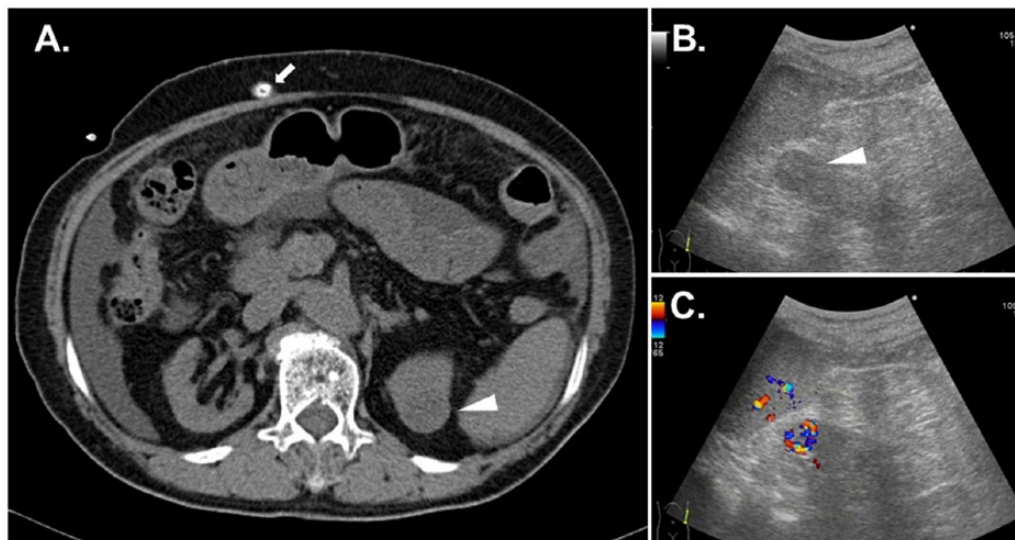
Findings of the imaging studies. A select axial image of a noncontrast abdominal computed tomographic scan (A) shows a solid mass with hypodense appearance deforming the contour in the upper pole of the left kidney (arrowhead). Note that the PD catheter within the wall of the abdomen is indicated (arrow). A longitudinal gray-scale ultrasound image (B) reveals a hypoechoic round shape mass in the corresponding region of the left kidney, whereas a peripheral vascular distribution with some penetration is demonstrated on color Doppler flow mapping (C).
